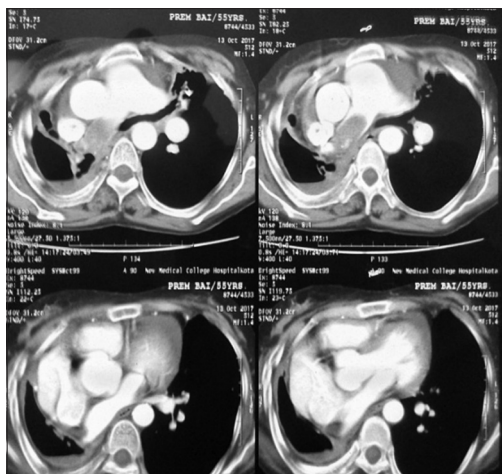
Contrast-enhanced computed tomography of the thorax demonstrating filling defect and cavitation with air-fluid level
